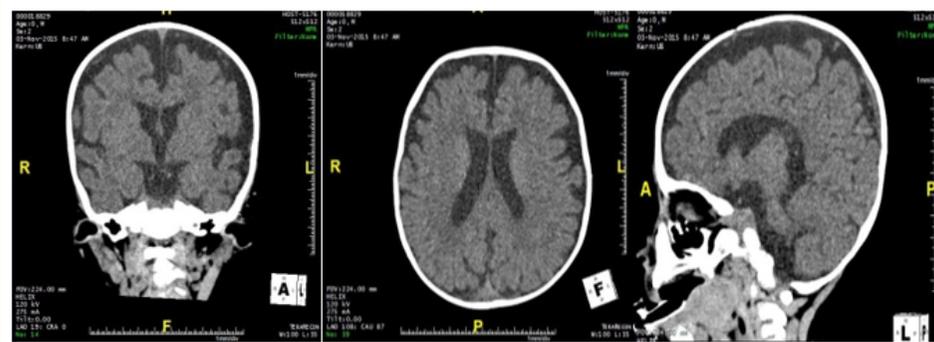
Baseline CT-scan. Cerebral atrophy and moderate enlargement of the ventricles and subarachnoid liquor structures have been detected.
